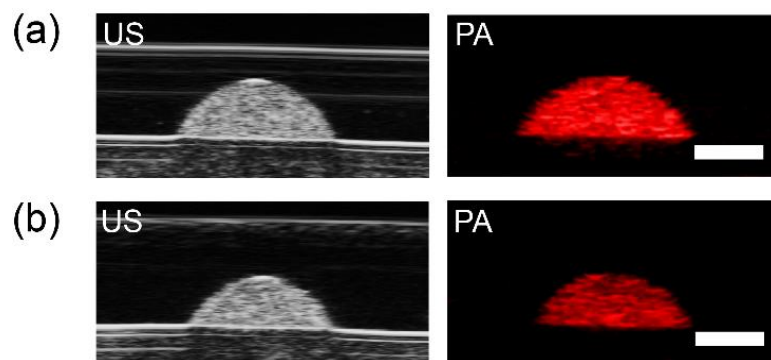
Ultrasound and photoacoustic images (scale bar = 2 mm) of gelatin inclusions containing (a) macrophages and (b) human breast cancer cells incubated with GSJNPs.
